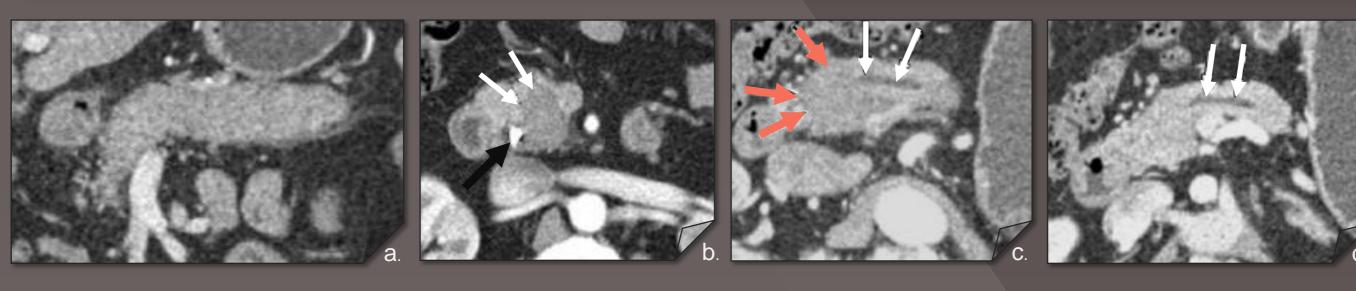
(a) Venous phase coronal reformatted CT image shows diffuse enlargement of the entire pancreas, without its normal lobular appearance. (b) Arterial phase axial CT image shows enlargement of the pancreatic head with a distinct area of decreased attenuation (white arrows). A stent is seen in the common bile duct (black arrow). (c) Arterial phase oblique axial reformatted CT image shows enlargement of the pancreatic head with a distinct area of decreased attenuation (orange arrows). The main pancreatic duct is minimally dilated (white arrows) proximal to the enlarged portion. (d) Venous phase oblique axial reformatted CT image of the same patient showing that the hypoattenuating area seen in the pancreatic head becomes nearly isoattenuating relative to adjacent pancretic parenchyma.
